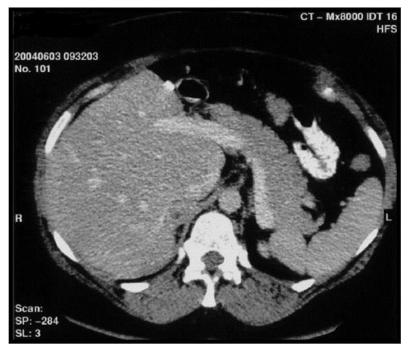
Computed tomography showing recurrence of a right adrenal pheochromocytoma. unpublished observation in a patient with MEN2-related bilateral pheochromocytomas and unilateral tumor recurrence 11 years after bilateral adrenalectomy, photo: courtesy of Prof. Andrea Tannapfel).
